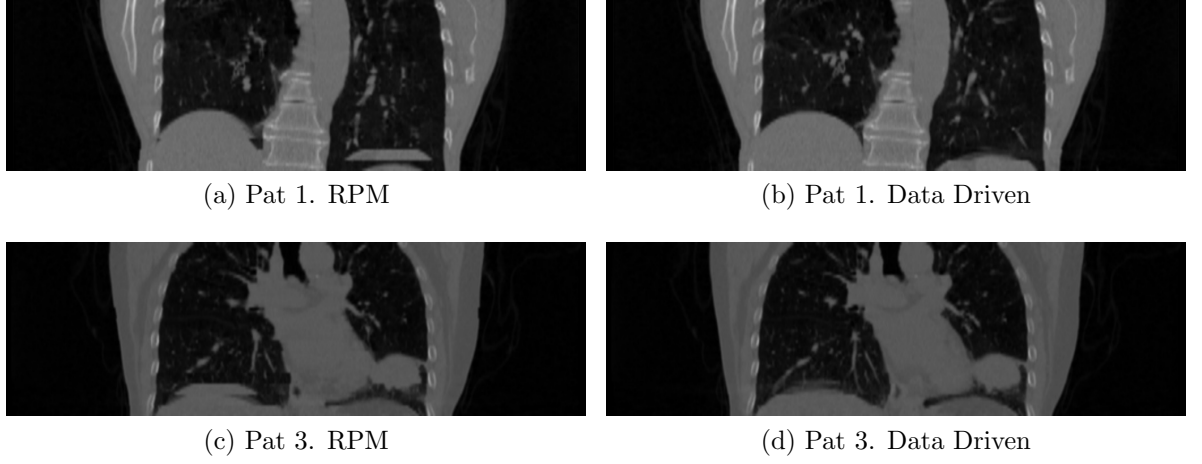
Coronal CT images for patients 1 bin 5 and patient 3 bin 6, RPM derived image demonstrating respiratory motion artefact, particularly at the diaphragm; data-driven image demonstrates reduced artefact.
